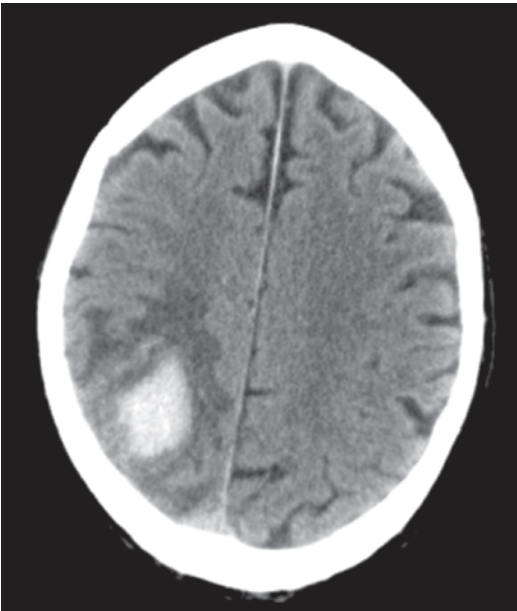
Computed tomography (CT) scan of acute lobar intracerebral hemorrhage in right fronto-parietal lobe with surrounding vasogenic edema due to amyloid angiopathy in an 80-year old man. (Courtesy of Blaine Hart, MD)
